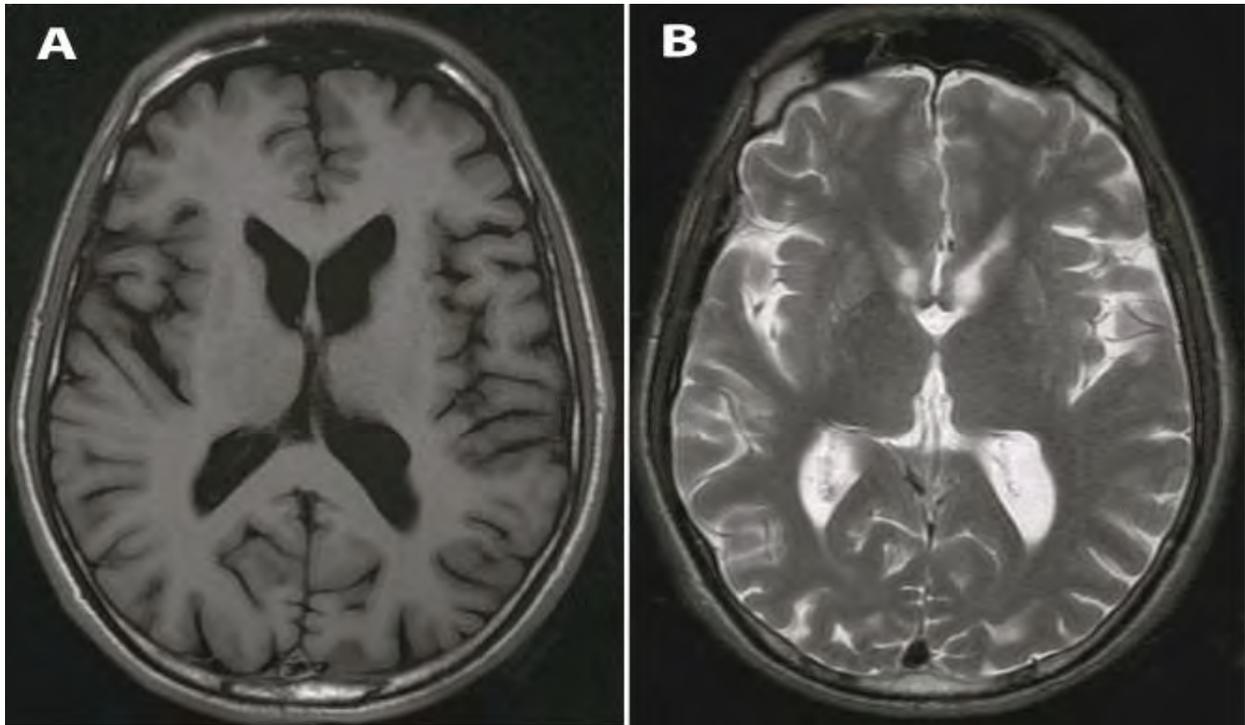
A representative brain MRI examination of patient with severe choreatic movement disorder. Bio-images of brain were obtained using the 1.5 T MRI systems (GE Healthcare, UK), with transverse T1- and T2-weighted scans at the level of basal ganglia. Fig. 1A indicates T1-weighted scan, whereas Fig. 1B indicates T2-weighted scan.
